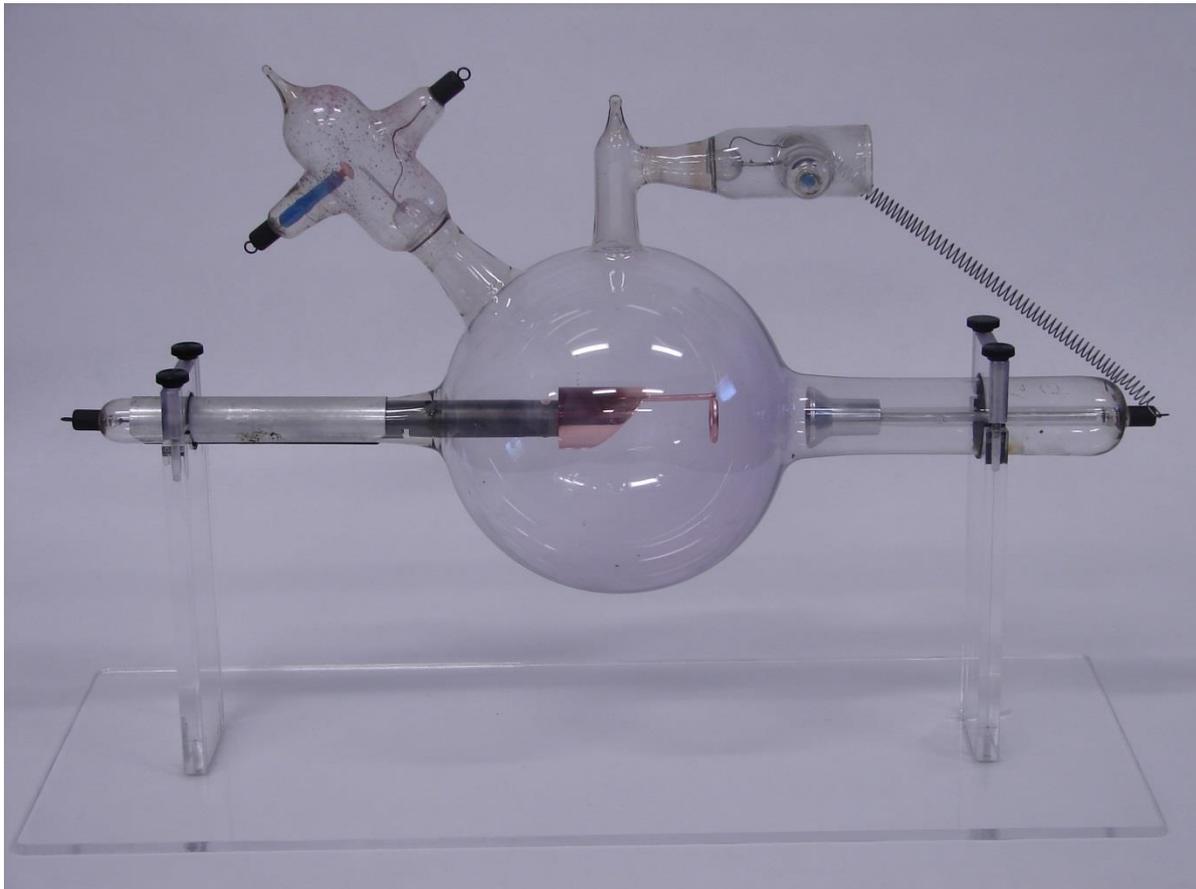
Hydrogen ion X-ray tube with field enhancing pull ring on anode potential, introduced in 1916 by the Victor X-Ray Company of Chicago, IL, later to be acquired by General Electric to become GEXCO, the forerunner of today's GE Healthcare. (Photo courtesy of GE.)
